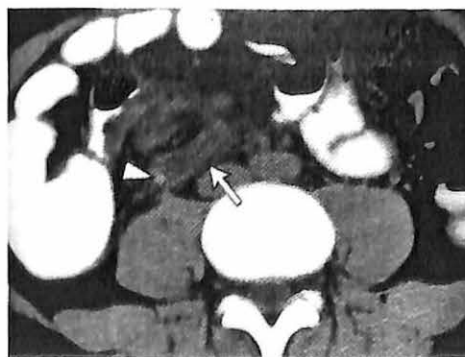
(c)(iii) shows the CT scan of the abdomen demonstrating an oedematous thickened appendix (arrow) with obstructing appendicolith (arrowhead).
